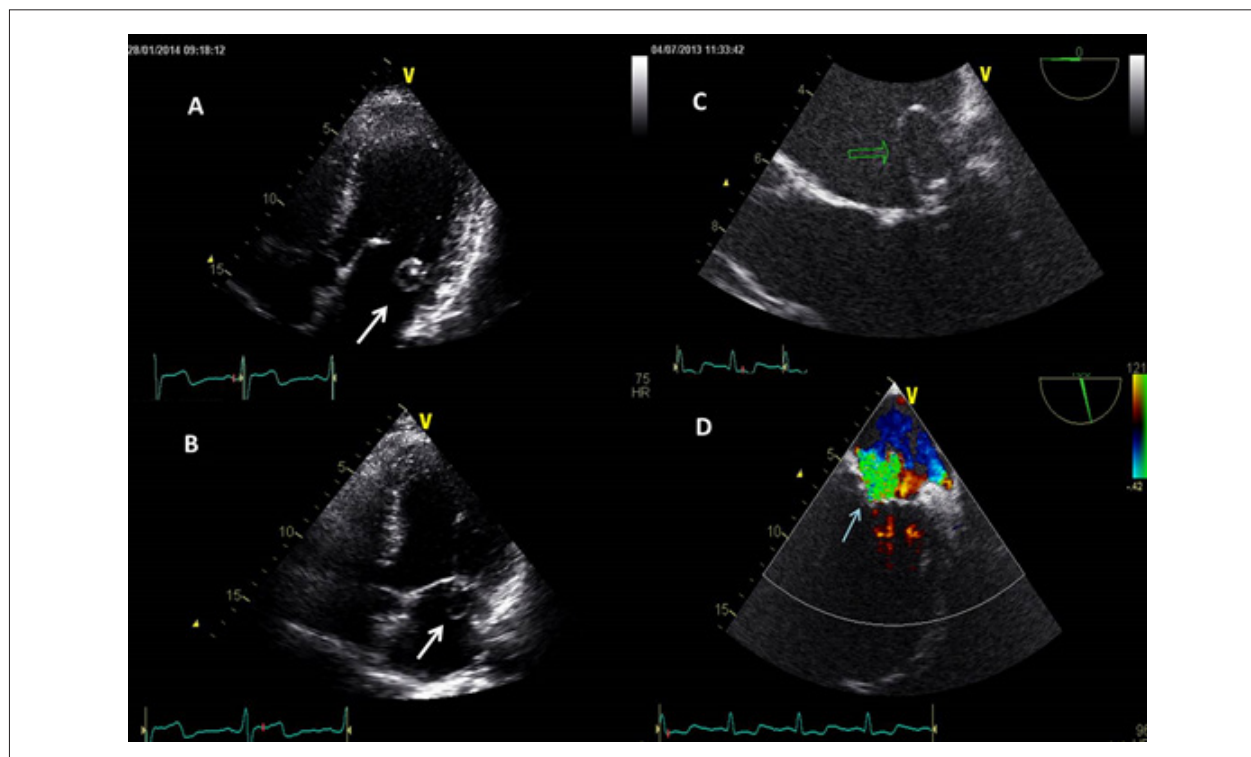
Transthoracic echocardiography (TTE): apical 4-chamber view – image of the calcified nodule on the posterior leaflet (P1–P2 transition), under which lies an aneurysm of the mitral valve in diastole (A) and systole (B) – white arrow. C. Transesophageal echocardiography (TEE): mid-esophageal 5-chamber view (0°) – image of saccular aneurysm on the posterior leaflet of the mitral valve (green arrow). D. TEE: mid-esophageal 2-chamber view: severe mitral regurgitation identified by color Doppler – blue arrow.
